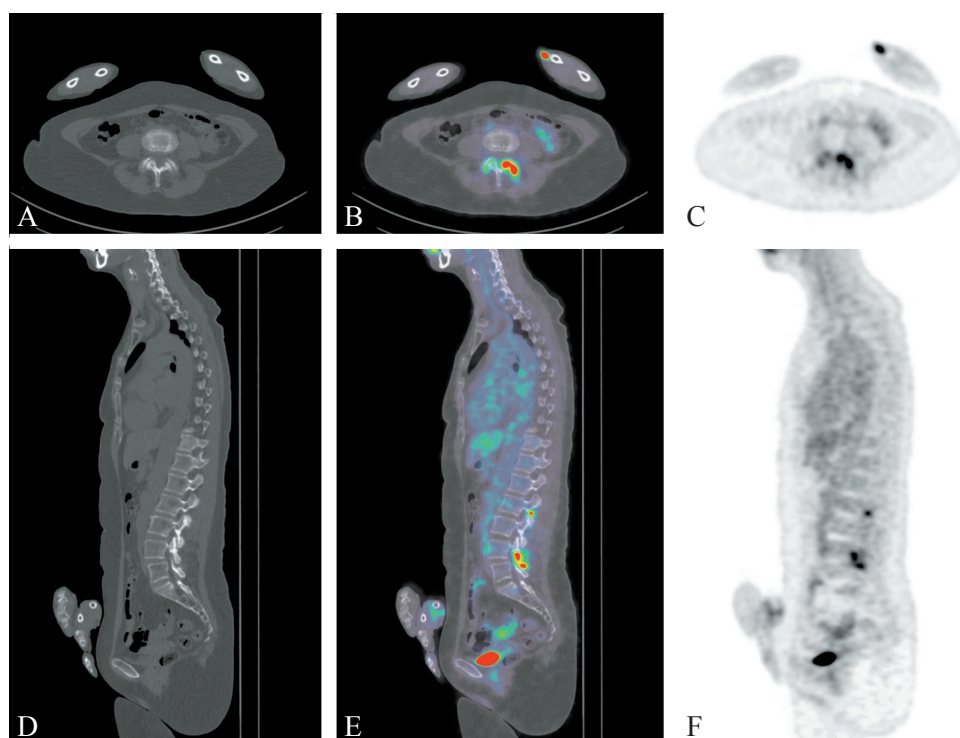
A 66-year-old female presenting with fever and lumbosacral pain. [^{18}F]FDG PET/CT reveals intense uptake at the left L4-L5 facet joint extending into the periarticular tissues, with lesser uptake observed at the right L4-L5 and left L2-L3 facet joints. CT images demonstrate erosions at the facet joints. Findings are consistent with multilevel septic facet joint arthritis. Axial CT (A) PET/CT fusion (B) and PET (C) images. Sagittal CT (D) PET/CT fusion (E) and PET (F) images.
